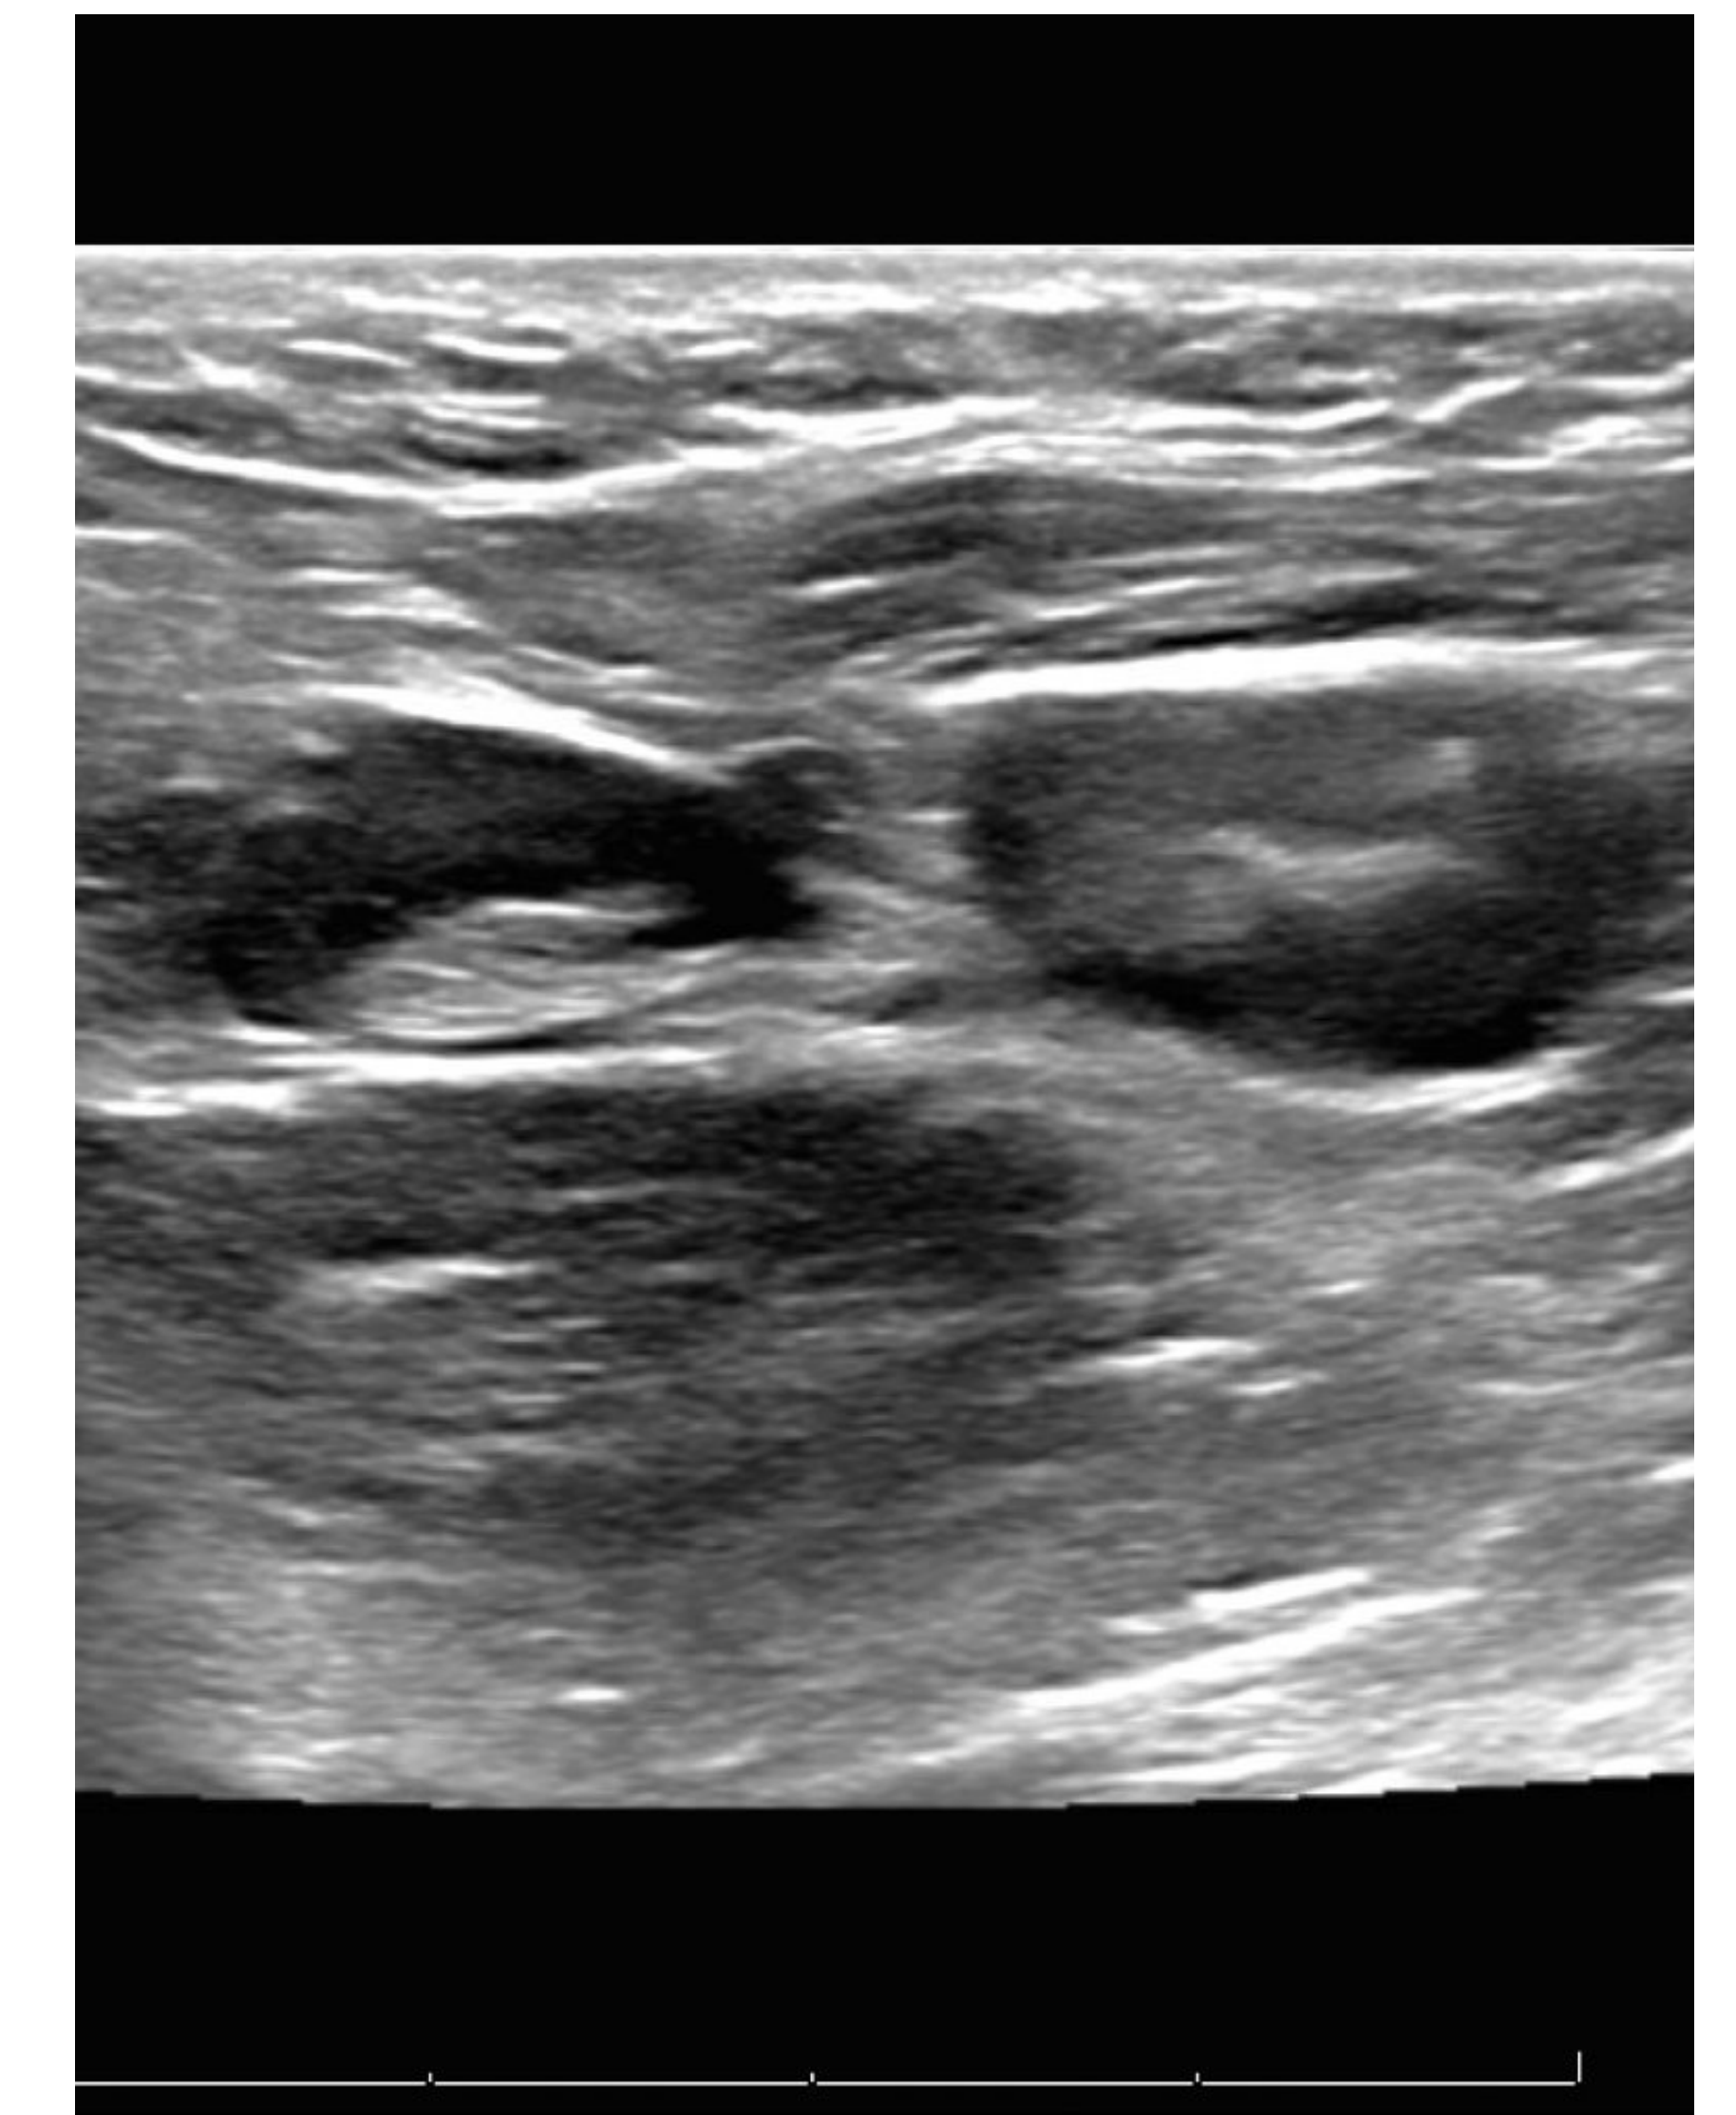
Ultrasound of the left breast showing multiple level 1 axillary lymph nodes with cortical thickening measuring up to 7 mm.
